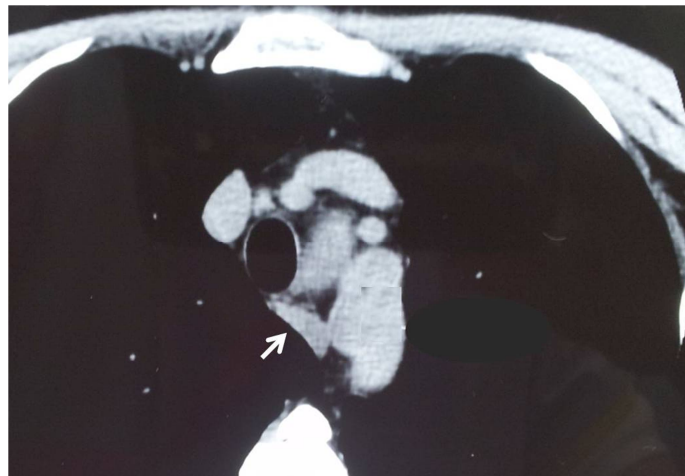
Axial CT Showing an Aberrant Right Subclavian Artery (Arrow).
